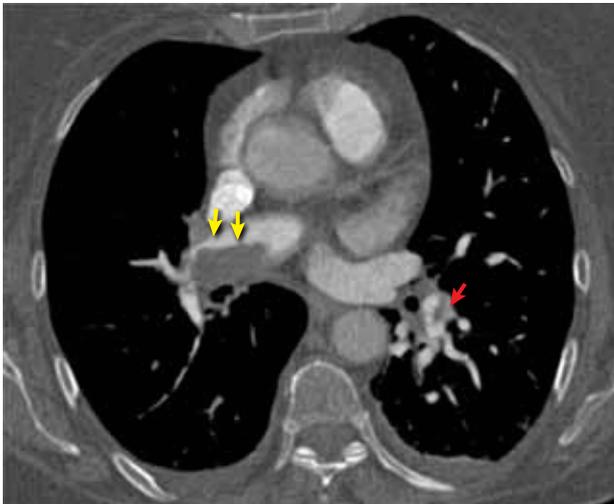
Axial contrast-enhanced CT scan shows an eccentric chronic thrombus producing irregular contours on the intimal surface of the right pulmonary artery (yellow arrows) and a web in the lumen of the left pulmonary artery (red arrow).
